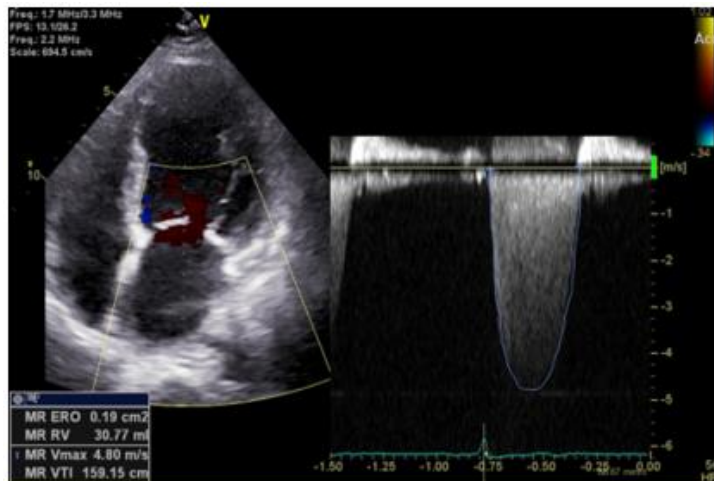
Preoperative transthoracic echocardiography (TTE). Apical view demonstrating moderate left ventricular systolic dysfunction and functional mitral regurgitation
